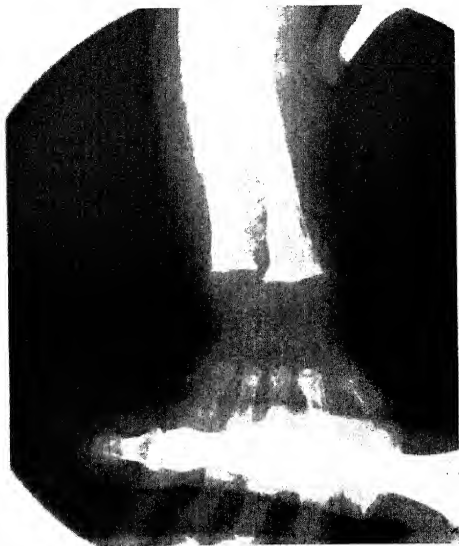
X-ray of wrist of 5½-month-old infant with rickets. Note cupping and flaring of lower ends of forearm bones and lack of development of wrist bones.
